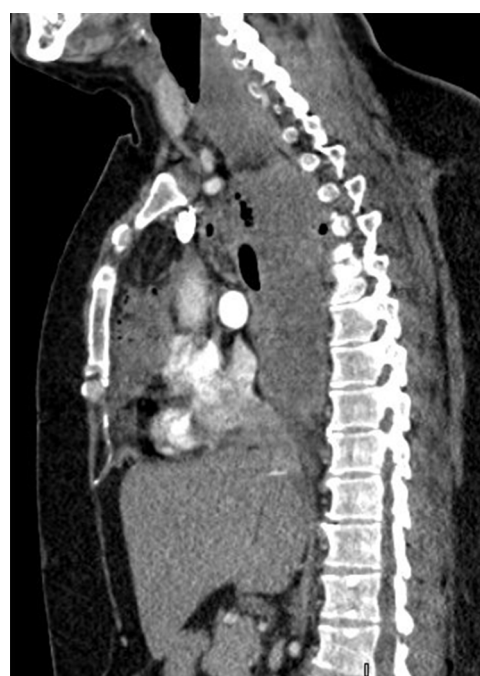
Computed tomography of the chest with intravenous contrast in sagittal section, with data of ENDO IIB mediastinitis, with fluid and gas collections at the cervical level, anterior and posterior mediastinum.
